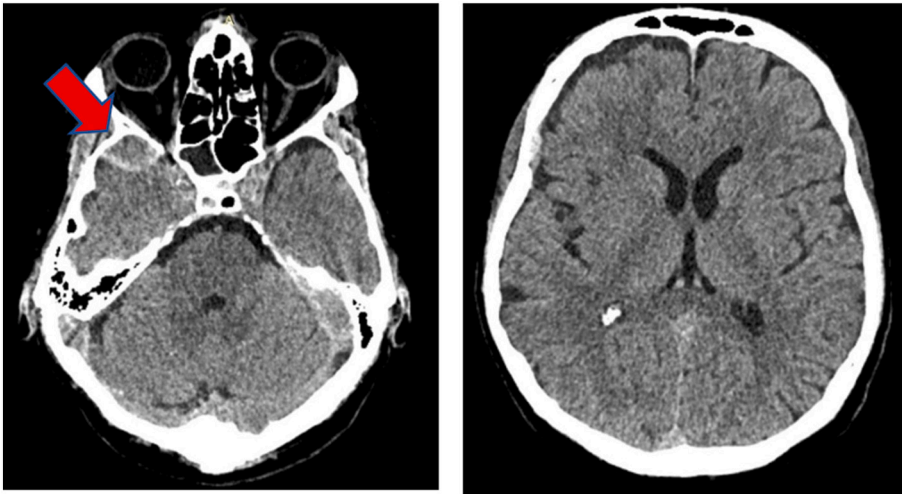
Control CT scan on the 5th day after the trauma. The epidural hematoma (red arrow) has not enlarged in diameter.
